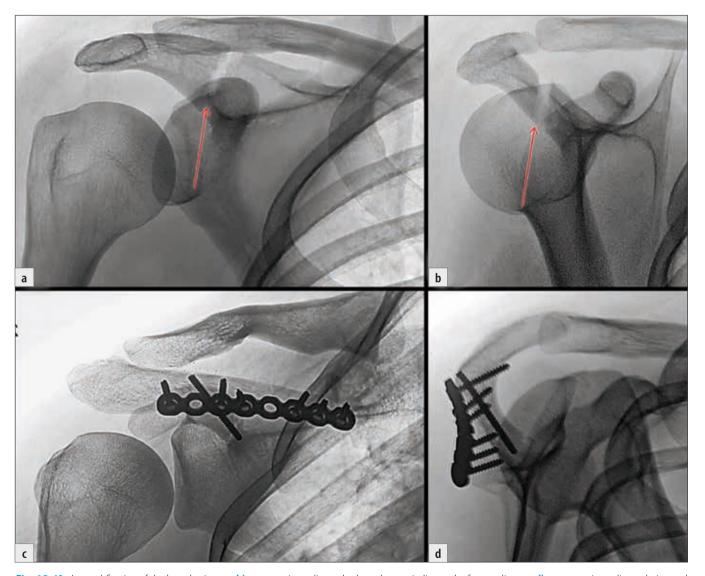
Internal fixation of the lateral spine: a+b) preoperative radiograph, the red arrow indicates the fracture line; c+d) postoperative radiograph, internal fixation performed with lag screw and neutralization plate. During tightening of the screw, the screw head broke off.
